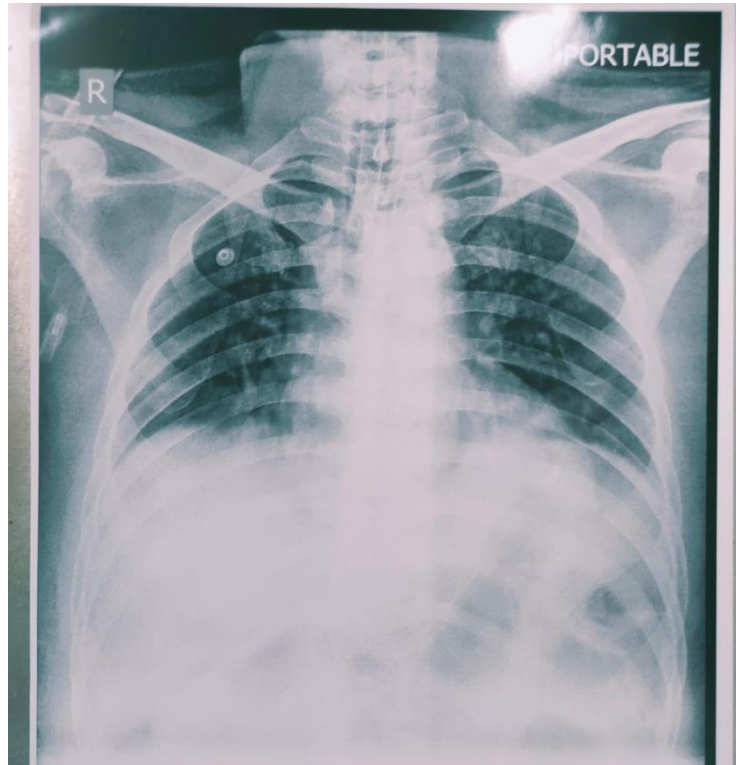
chest x-ray on POD 2
